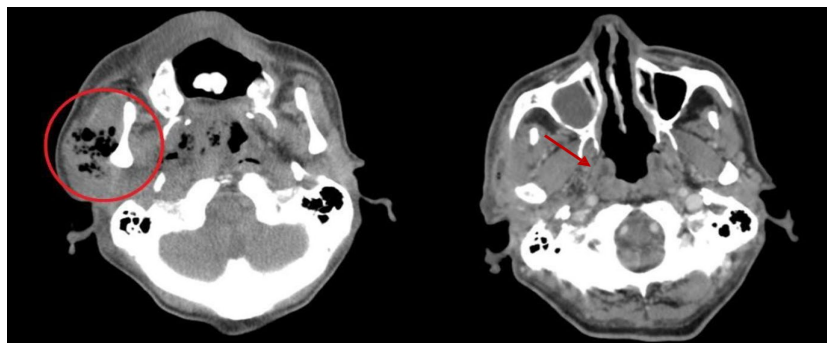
Radiographic comparison of Head and Neck Ct scan: Left panel, image from admission, right panel, image from 4 weeks of antibiotic therapy. On admission noted rim-enhancing collection in the right lateral cervical region with loculations and surrounding inflammatory changes, consistent with abscess formation. The primary collection measured approximately $15.2 \times 11.8 \times 7.6$ cm (craniocaudal \times width \times anteroposterior), with an estimated volume of 708.8 cc. After 4 weeks of Intravenous antibiotics, complete resolution of rim-enhancing collection in the right lateral cervical region involving the right submandibular, masticator and parotid spaces.
